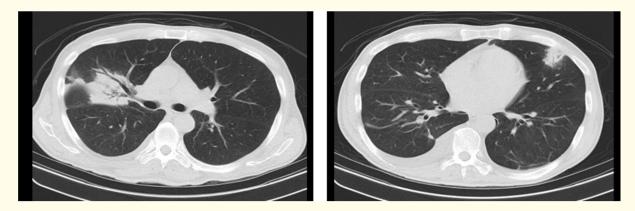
Computed tomography scan 5 days following the initial scan showing evolution and improvement in the consolidations.
